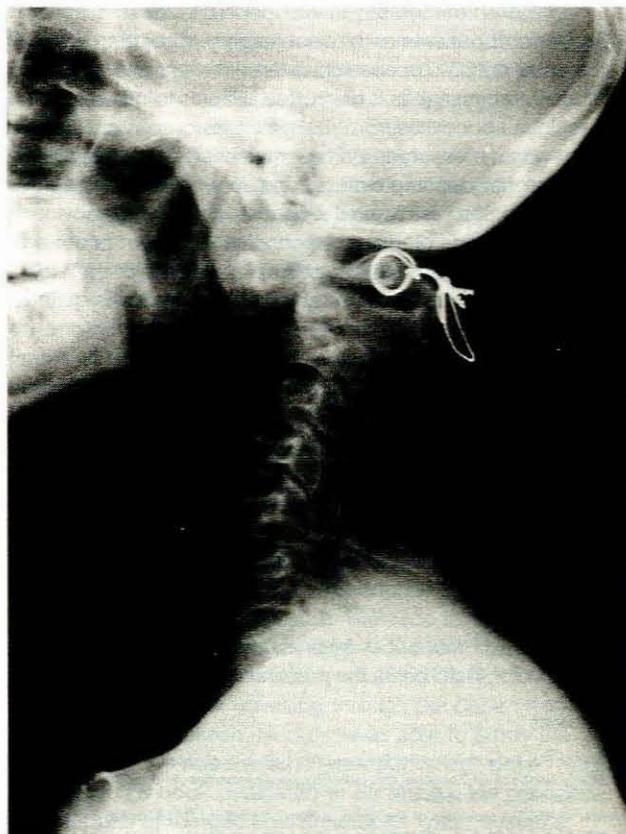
Case 2. Radiograph showing C1 and C2 fused in a subluxed position 6 months after operation.
